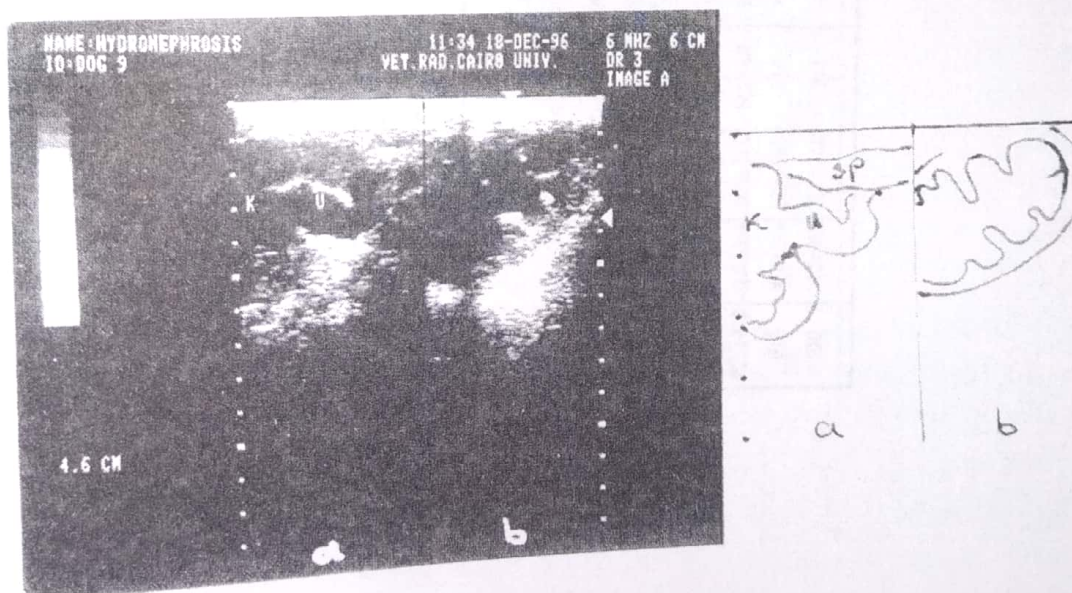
Ultrasonographic image of kidney and ureter by 6 MHz linear array:
